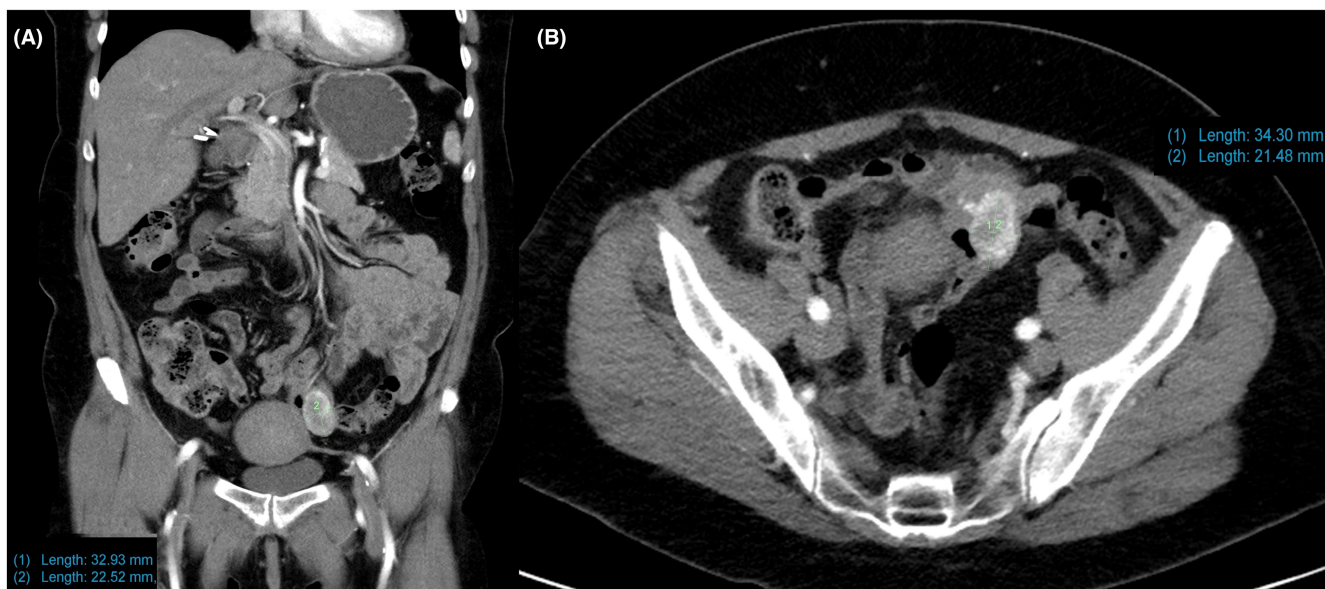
(A) Coronal CT showing GIST in ileum. (B) Axial CT showing GIST in ileum. Abbreviations: CT, Computerized Tomography. GIST, Gastrointestinal Stromal Tumors. Credit: David Hugo Romero
